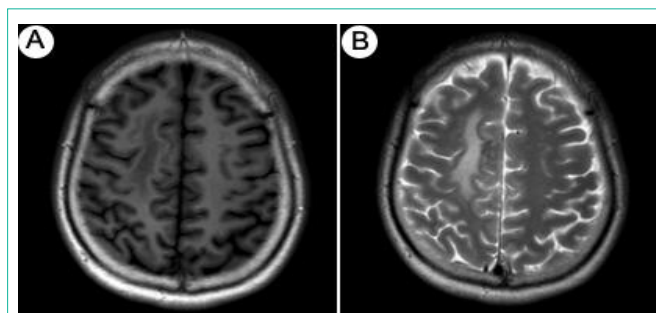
Picture A is T1-weight images and picture B is T2-weight Images. The second evaluation of MRI showing the volume of cerebral infarction narrowed after therapy one month later.
